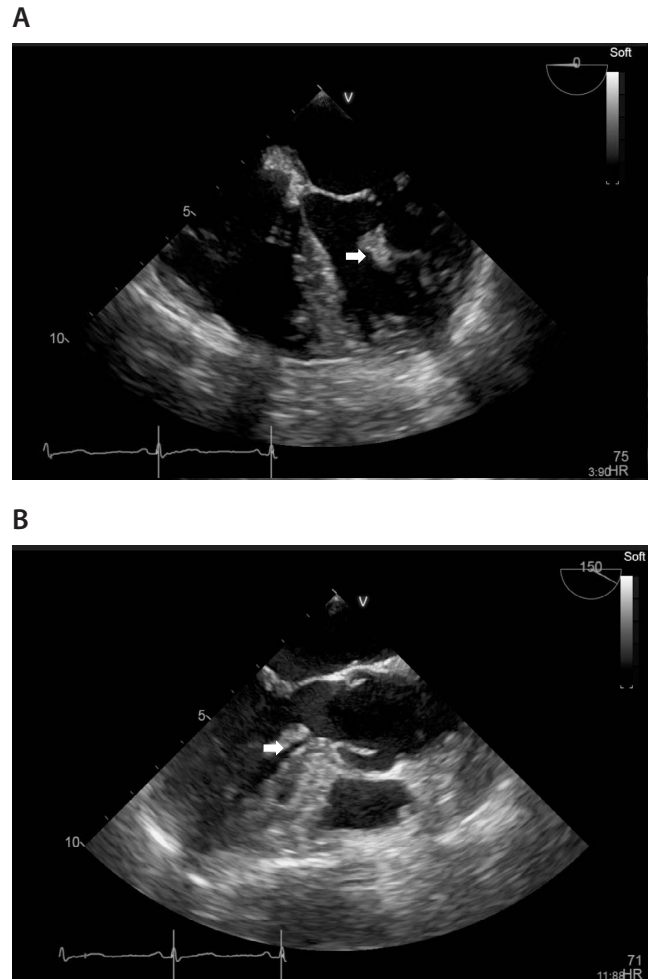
Transesophageal Echocardiogram Showing a Stretched Mass (Arrow) Located in the Left Ventricular Outflow Tract During Systole
